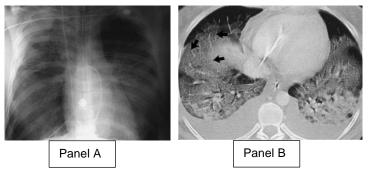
Lungs of a patients diagnosed with acute respiratory distress syndrome (ARDS). Panel A shows a chest radiograph from a 42-year-old man with ARDS. The lung shows diffuse alveolar opacities, which is consistent with pulmonary edema. Panel B displays a CT-scan of the chest. The alveolar opacities are more dense in the posterior lung. The arrows display thickened interlobular septa, consistent with the presence of pulmonary edema⁶.
